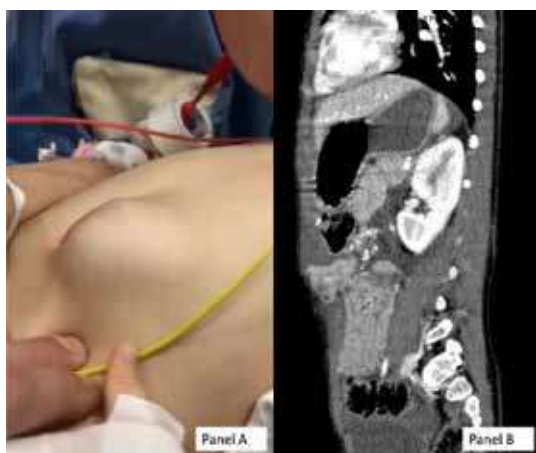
A) left abdominal wall swelling at presentation in the emergency department; B) sagittal plane of CT showing the anterior abdominal wall hernia.
